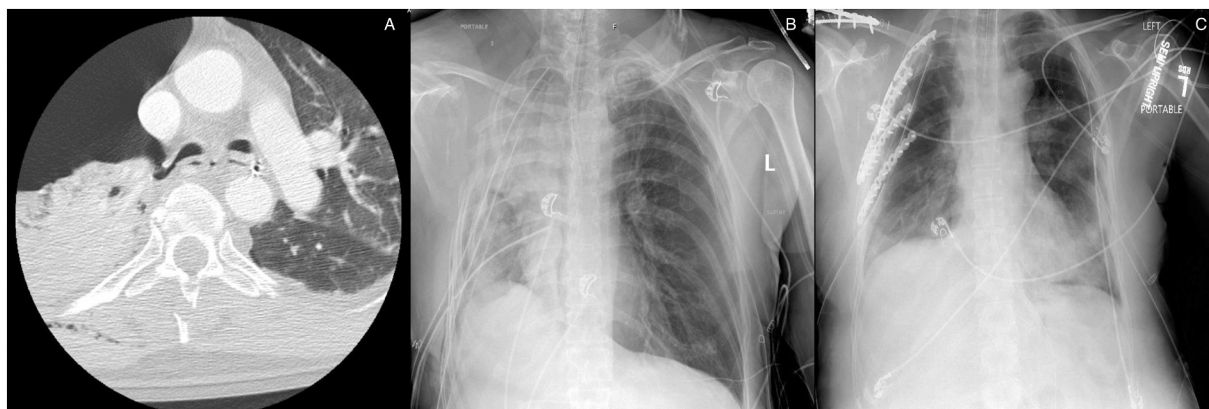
(A) Axial CT showing complete transection of right mainstem bronchus. (B) Chest X-Ray showing extent of right lung collapse prior to surgery; (C) chest X-ray on post-op day 11.
